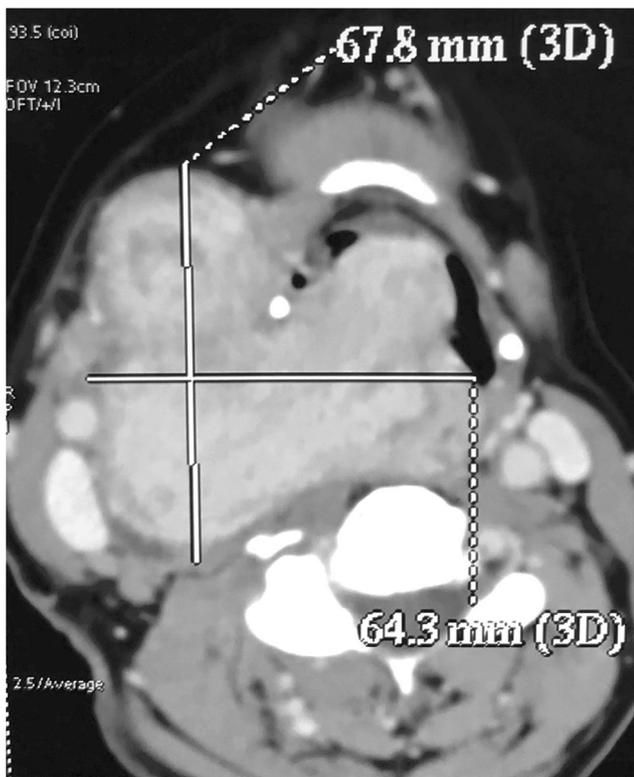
Axial CT scan of the upper neck showing $6.8 \times 6.4 \times 6.1$ cm lobulated heterogeneously enhancing mass lesion with few non-enhancing cystic areas. The mass is narrowing the upper airway with displacement of the carotid artery IJV laterally
